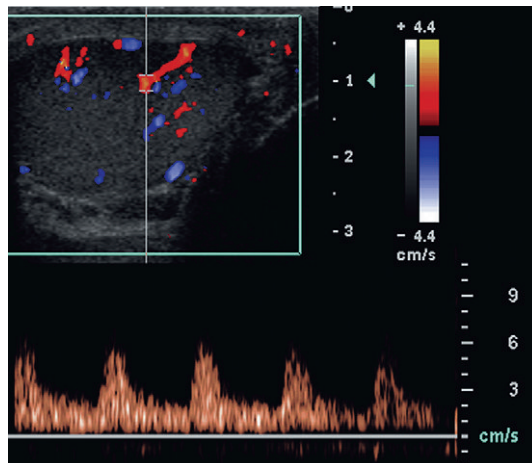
Spectral Doppler waveform of a normal testicle. The resistive index is a normal (approx. 70%).
